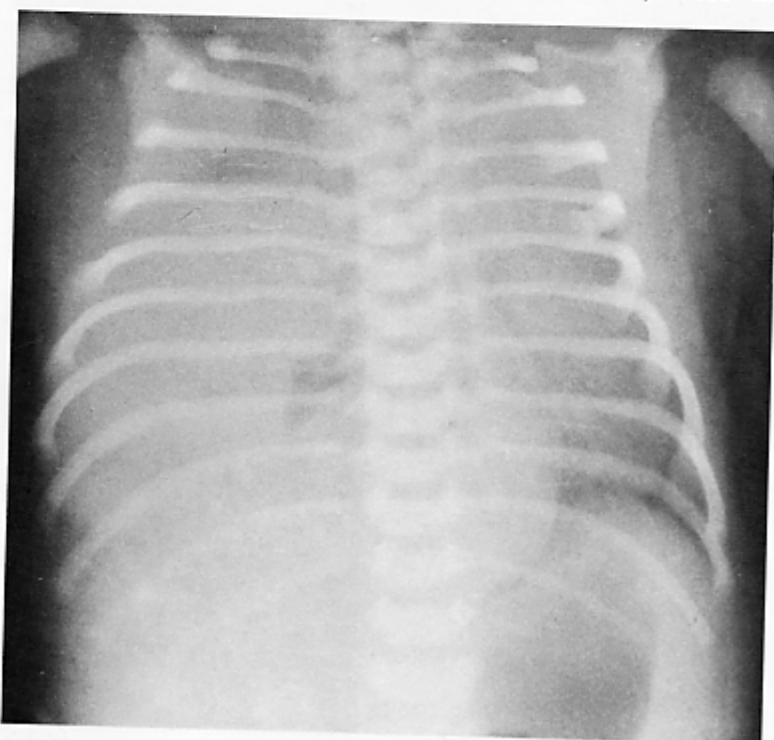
Chest x-ray film at birth.
